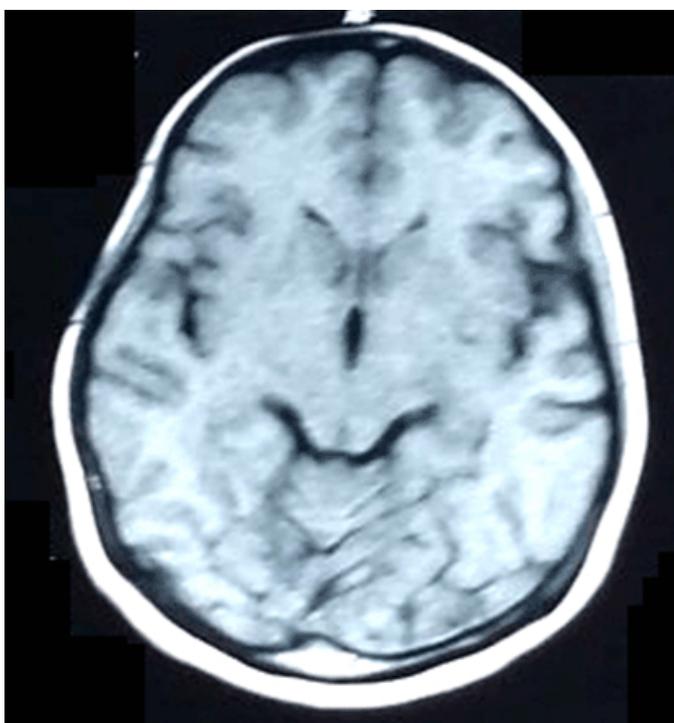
Magnetic resonance imaging scan of Brain without contrast: Essentially normal study.
